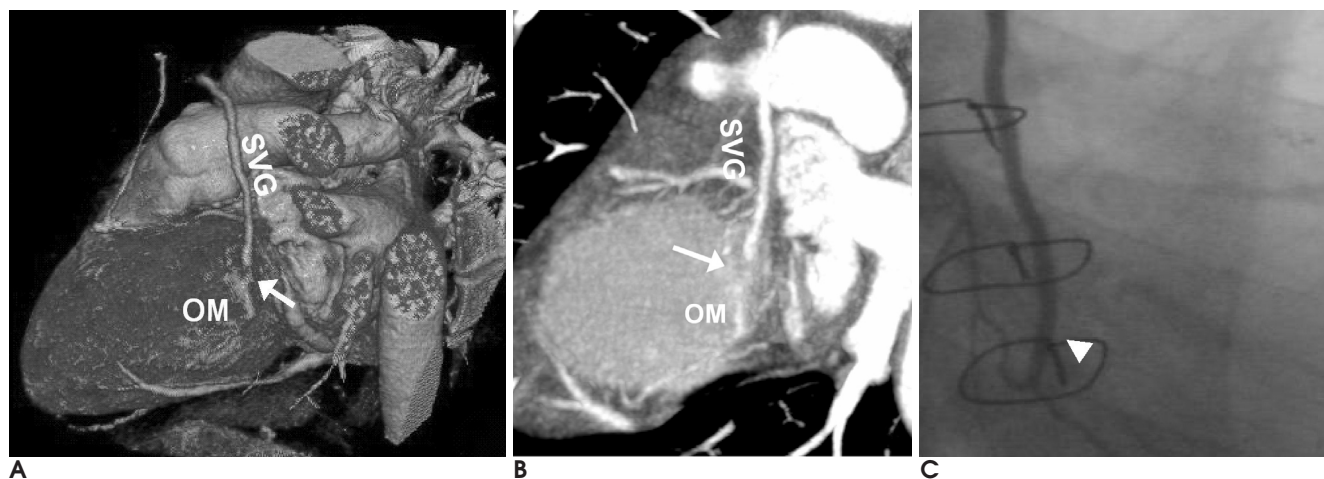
An example of false positive diagnosis. A 60-year-old male patient received CABG, two months before CTA and CAG. The heart rate was 90 bpm. On VRT (A) and selected MIP (B) images, anastomosis site between saphenous vein graft (SVG) and OM branch (arrows) is blurred, mimicking stenosis. However, CAG (C) shows patent anastomosis site (arrowhead).
